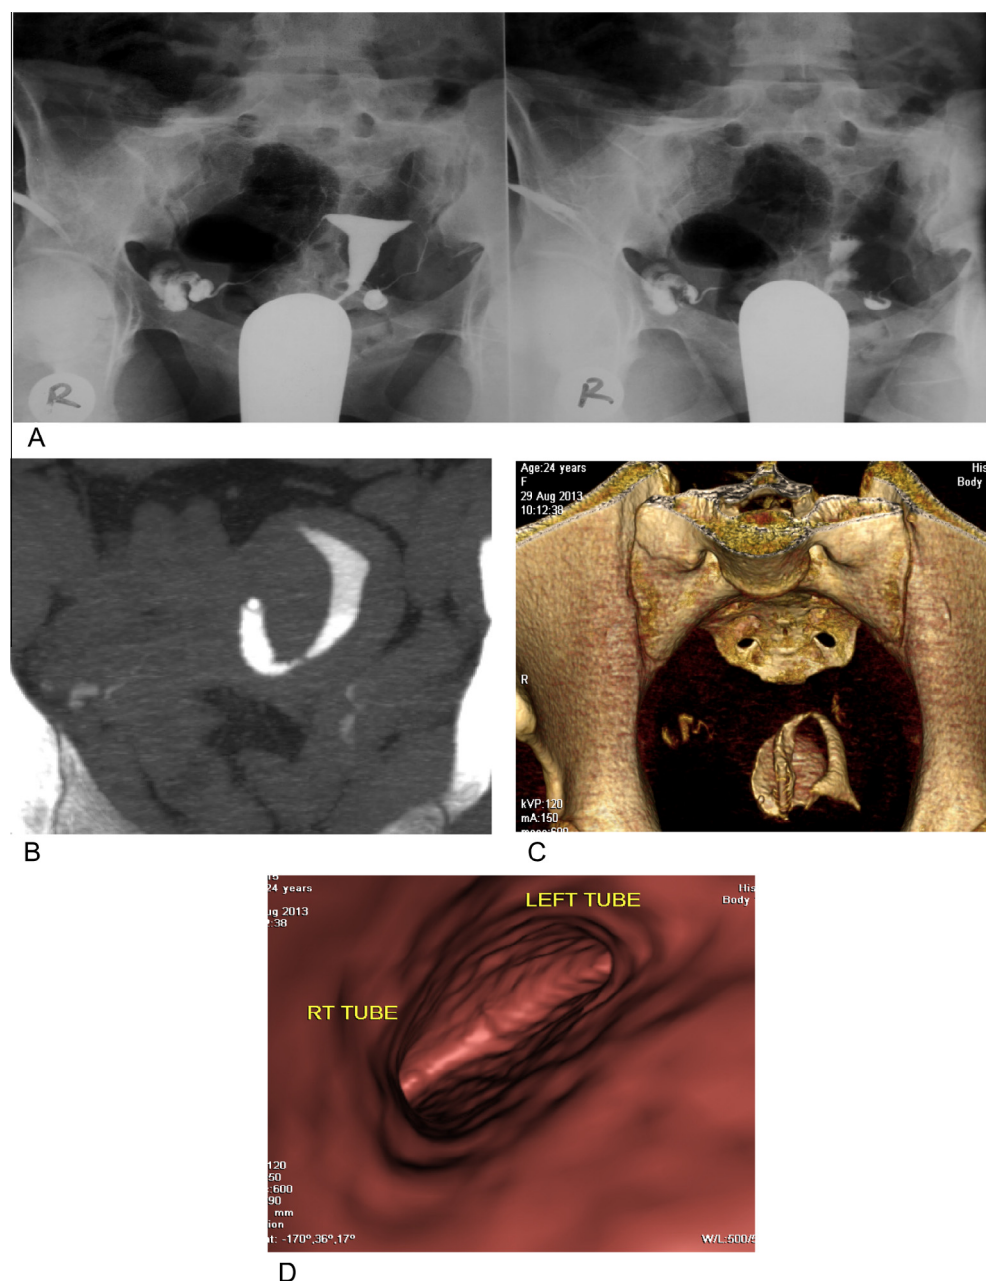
Bilateral hydrosalpinx. (A) The X-ray HSG revealed bilateral hydrosalpinx. The MDCT VHSG revealed bilateral hydrosalpinx, (B) maximum intensity projections. (C) Volume rendering reconstruction. (D) Virtual endoscopic view.
